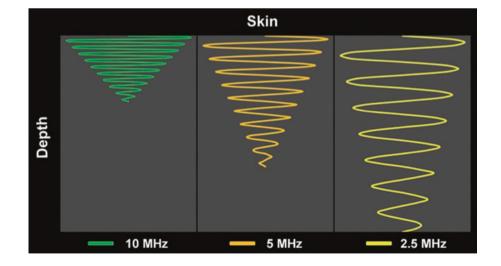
Axial resolution denotes the ability of the ultrasound machine to visually separate two structures lying atop one another (*y*-axis) in a direction parallel to the beam. As frequency increases, axial resolution increases, but depth of penetration decreases. Low-frequency waves
